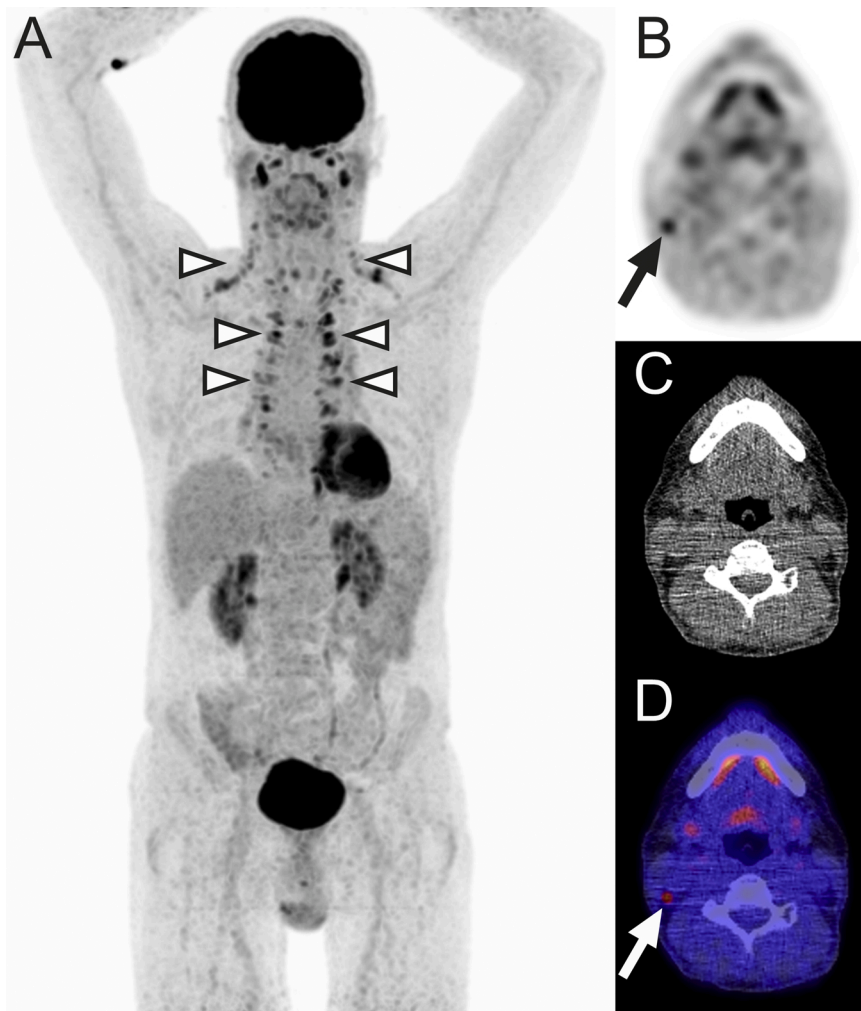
A 59-year-old man who had received chemoradiation therapy for right-sided tonsillar cancer. Low-dose FDG-PET/CT was performed for staging purposes. Coronal maximum intensity projection FDG-PET (A), axial FDG-PET (B), axial low-dose CT (C), and axial fused FDG-PET/CT (D) are demonstrated. FDG-PET showed physiological FDG-avid brown fat in the bilateral cervical and paravertebral regions (A, arrowheads). Furthermore, an FDG-avid focus in the right side of the neck (B and D, arrows) was described as a possible lymph node metastasis in the original report. However, CT image at the same level (C) showed the FDG-avid focus in the right side of the neck to be localized in fatty tissue, and not in a lymph node. Therefore, it most likely also represented physiological FDG-avid brown fat. This cognitive error was corrected with an addendum two days after authorization of the original report.
